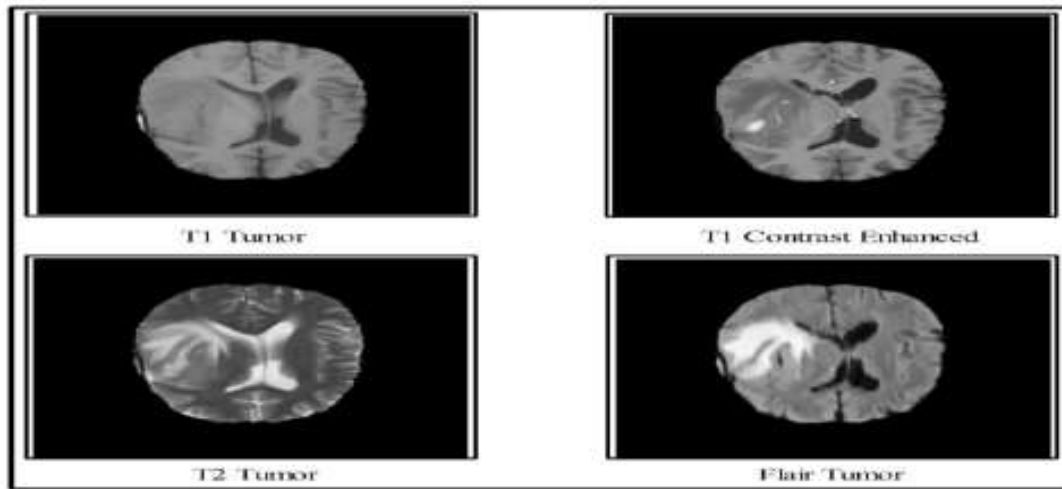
Representative multimodal brain MRI scans (T1, T1c, T2, and FLAIR).
